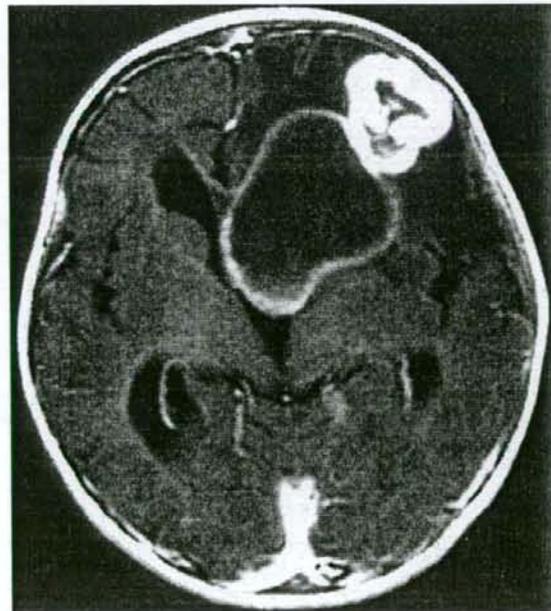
Gadolinium-enhanced T1-weighted MR image reveals a heterogeneous enhancing mass attached to the dura in the left frontal convex. The mass accompanies a large and thickly enhancing cyst in the deep white matter.
